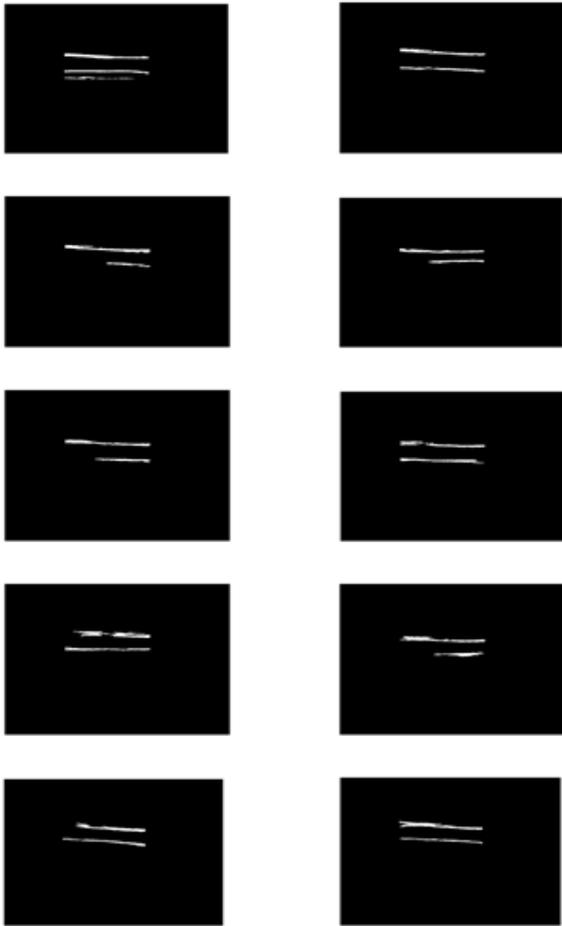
Results of 10 females carotid artery ultrasound images
